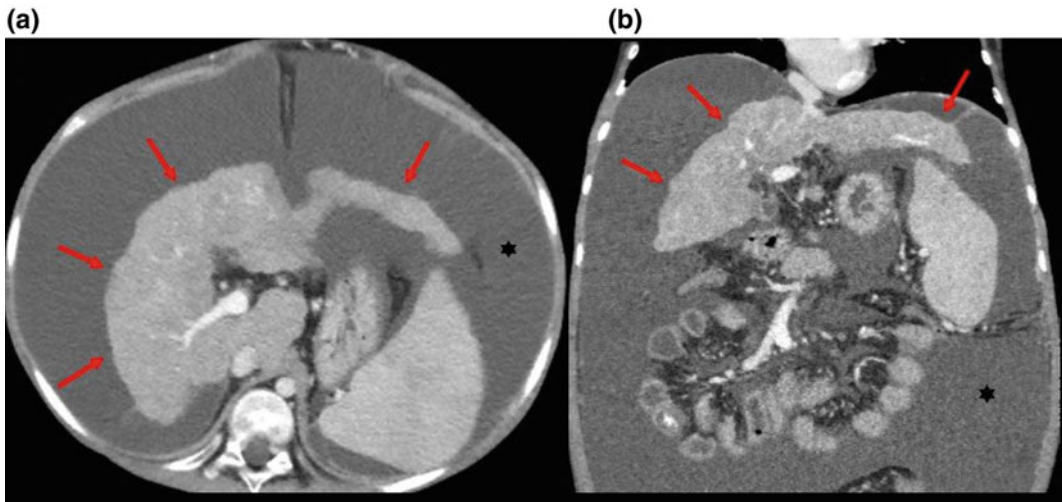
Gross changes of liver cirrhosis seen on an axial (a) and coronal (b) images from an enhanced CT scan. The liver is shrunken with an irregular nodular contour (*arrows*) and surrounding ascitic fluid (*asterisks*)
